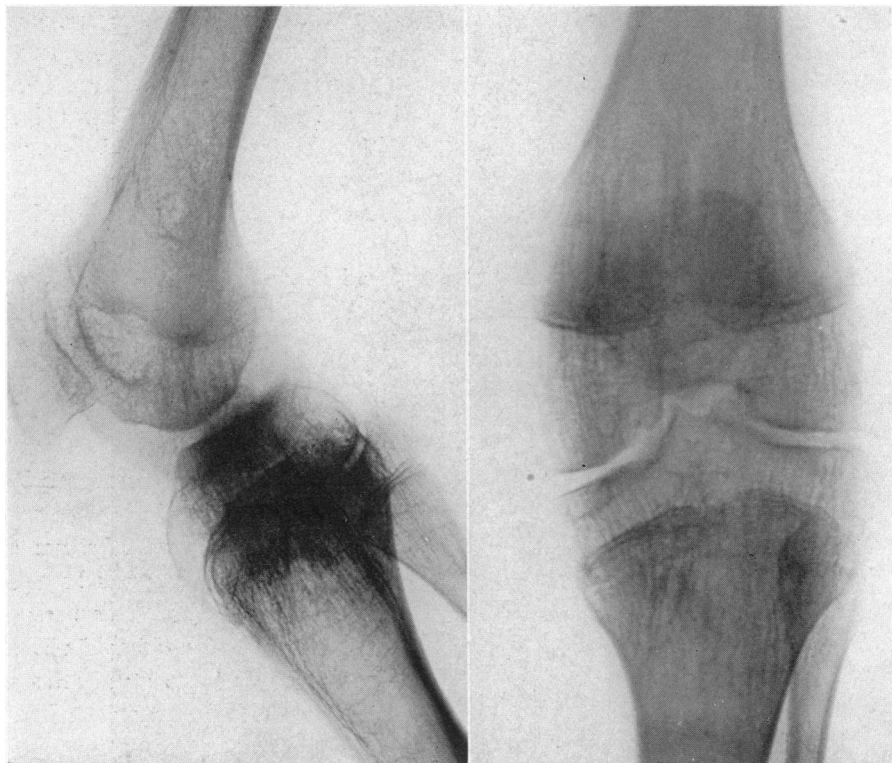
X-rays of operated case one and one-half years after operation. Note the increased roughening in the joint and the decrease in the bone atrophy. The large rarefied area in the femur persists and the opaque synovial tissue which was removed at the operation is absent in the film.
